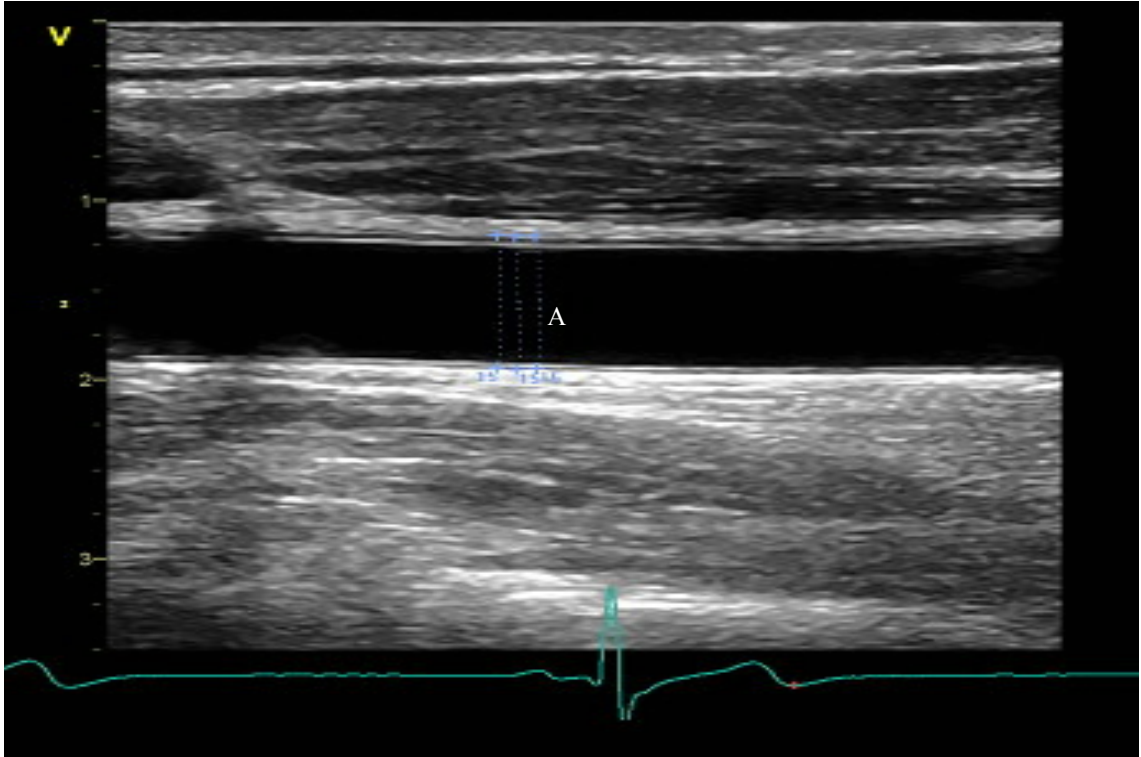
Figure B-1. Longitudinal view of the right CCA (common carotid artery) using B-mode ultrasonography. Note: diameter measurements were taken using EchoPAC calipers (A).
